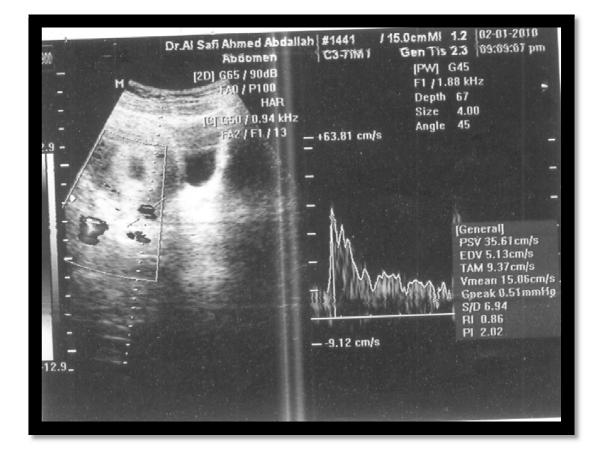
A39 pregnant patient with a history of (RPL) the abdominal color Doppler scan shows threatened abortion.
